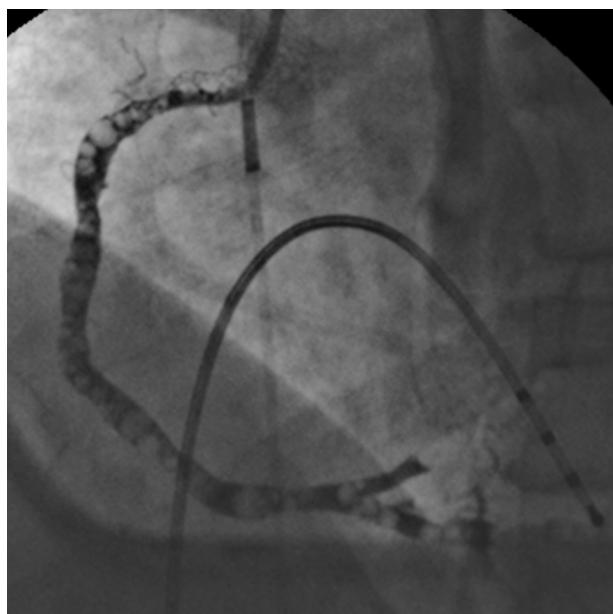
Right coronary artery (RCA) angiography in the left anterior oblique view. Extensive air bubbles were shown to fill the entire RCA. An intracardiac ultrasound catheter and temporary pacing catheter are also shown in the figure. The transseptal apparatus has already been removed. The left coronary artery was not involved (not shown).
